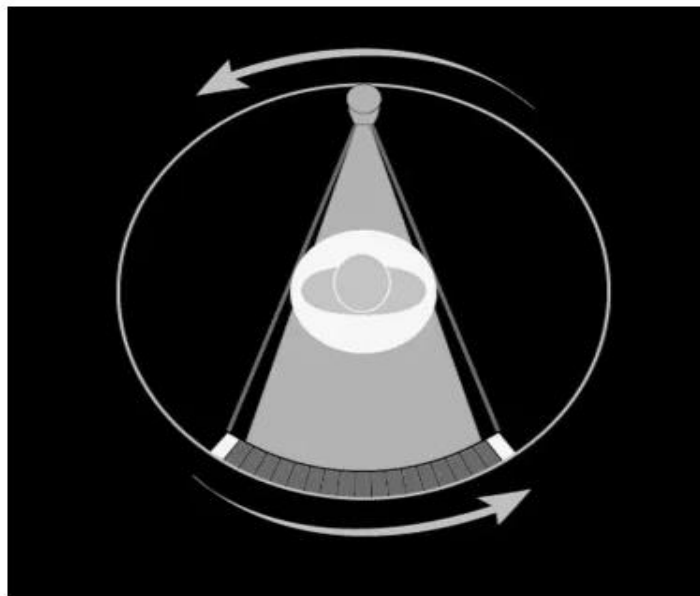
A simple CT scan produces a one-dimensional strip radiograph for each projection through the patient.
